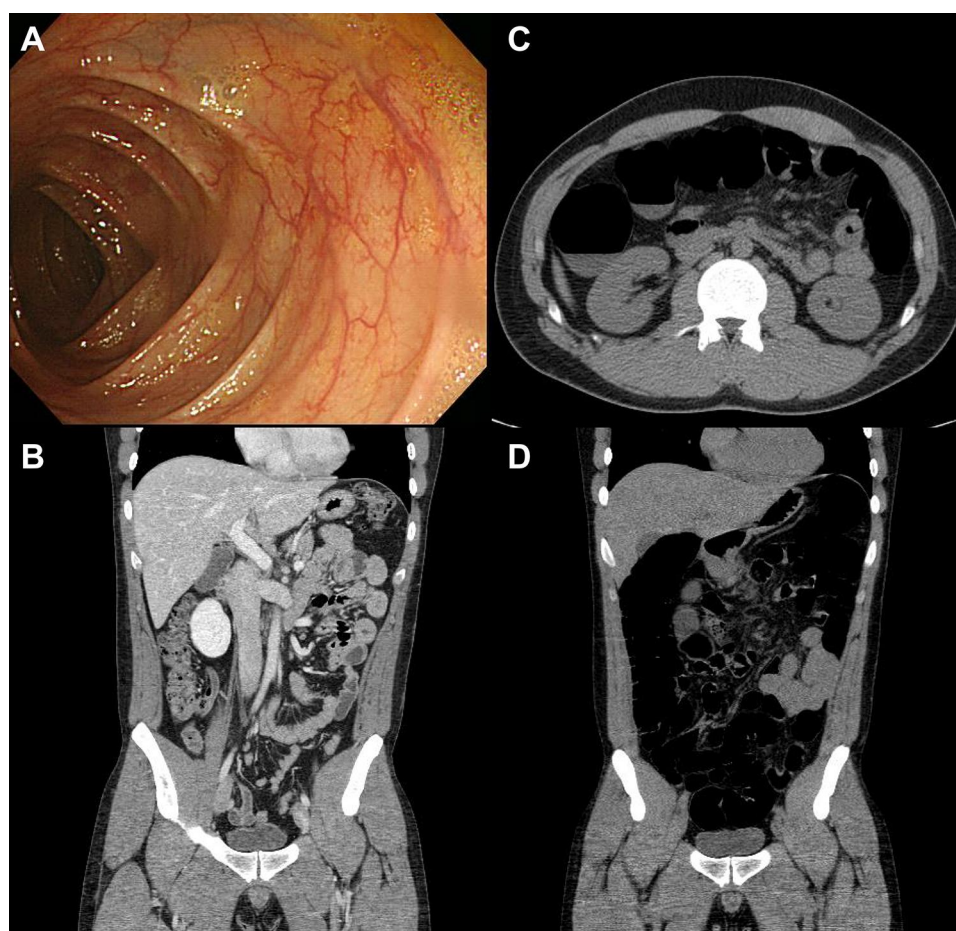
Colonoscopy (A), follow-up computed tomography (CT) scan (B), and colonography protocol CT scan (C and D), performed two weeks after discharge, showed no significant abnormalities.
